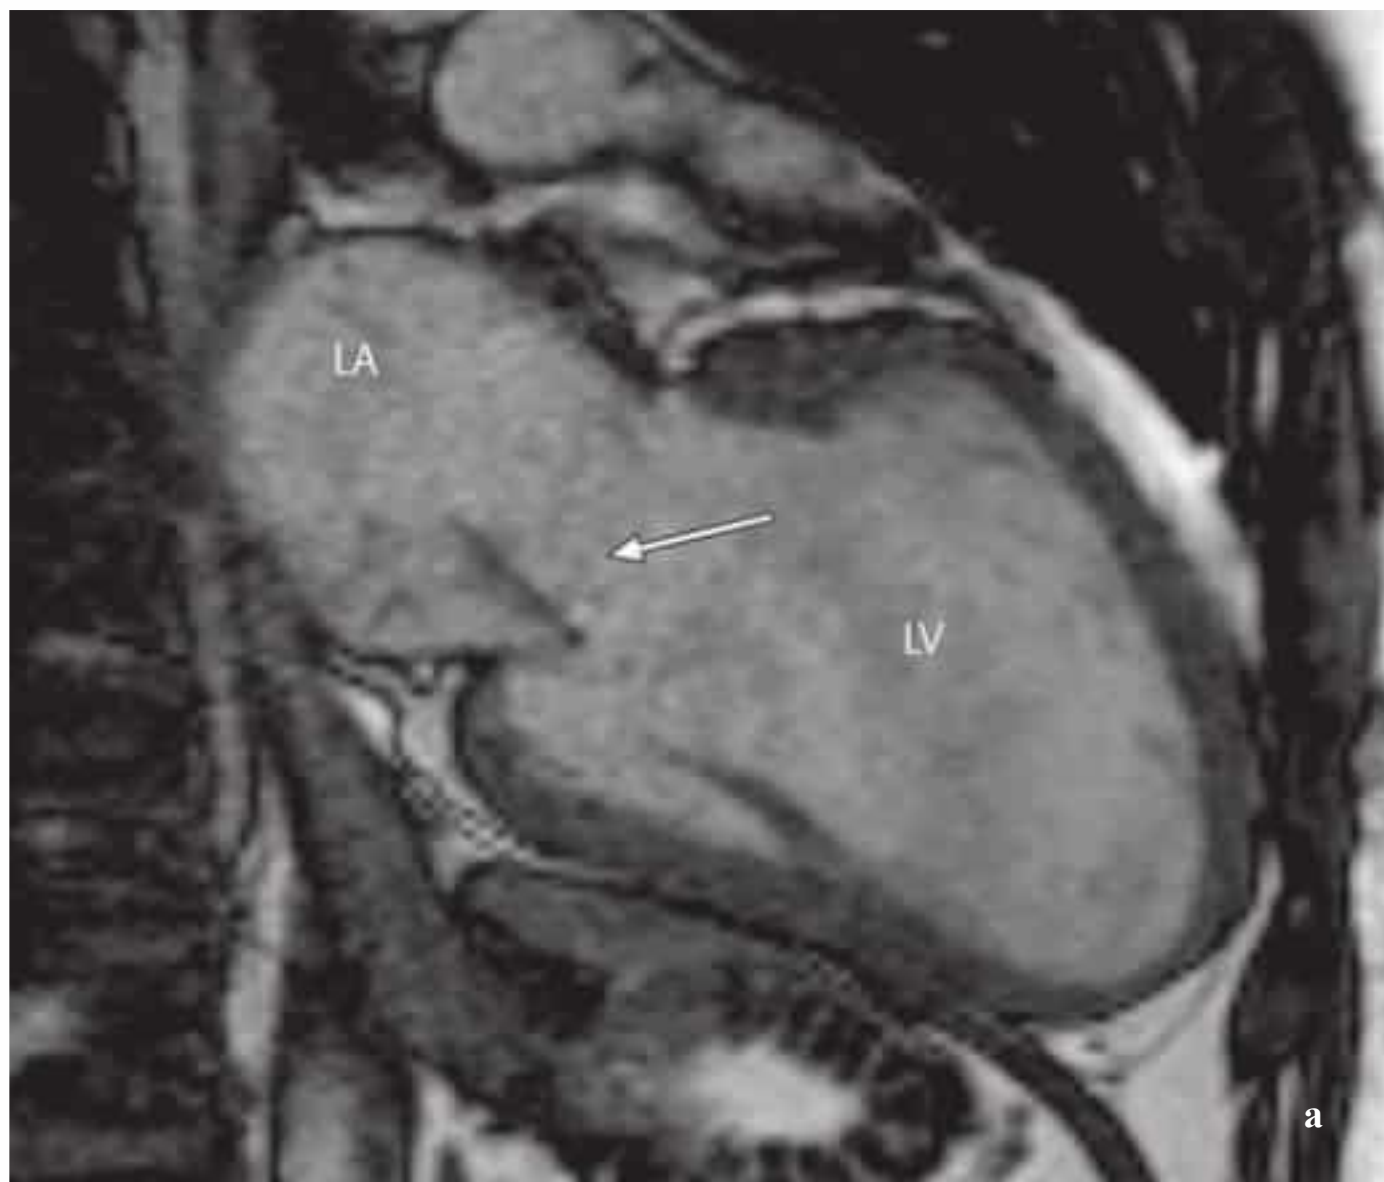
a, b Mitral insufficiency in a 22-year-old man. MRI clearly demonstrates a systolic jet (arrow) regurgitating across the mitral valve into the left atrium. Quantification indicated a regurgitant fraction of 28 %
